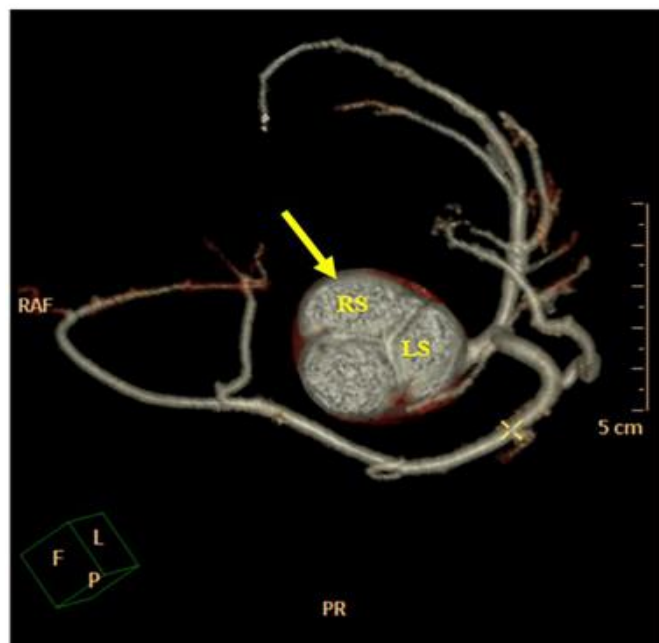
Single coronary artery type Lipton LI: Coronary computed tomography, volume-rendering technique (VRT) scan reconstruction: sagittal view. Right sinus (RS) left sinus (LS).
